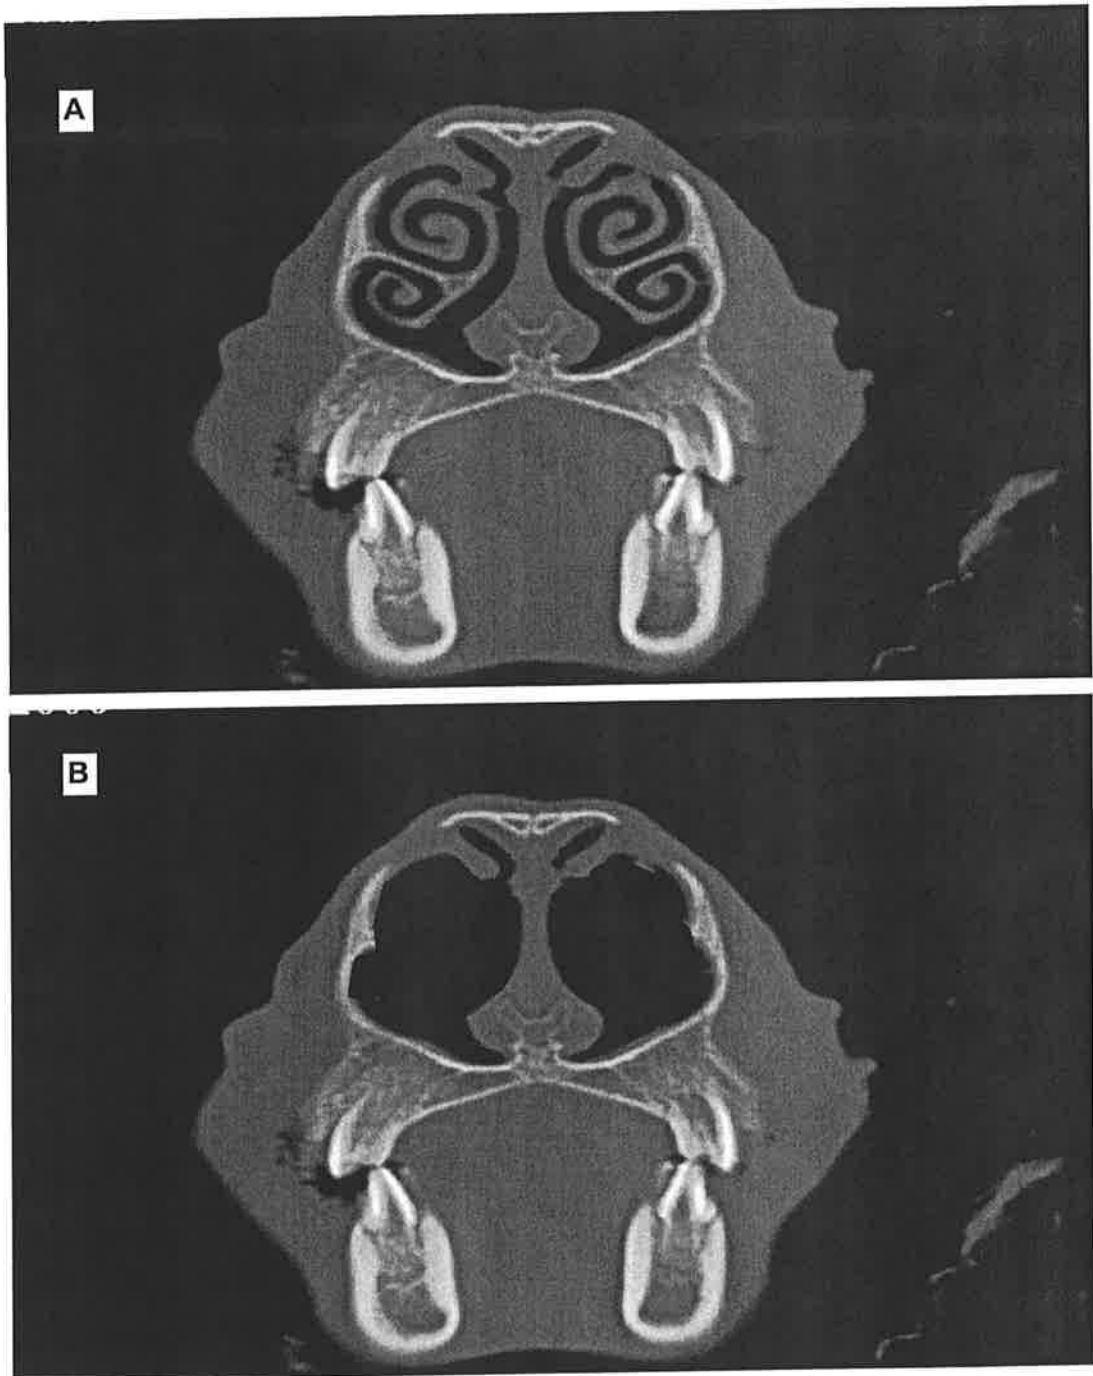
Computer generated CT-scan image demonstrating effect of middle turbinate removal. A) Before removal, B) After removal.
